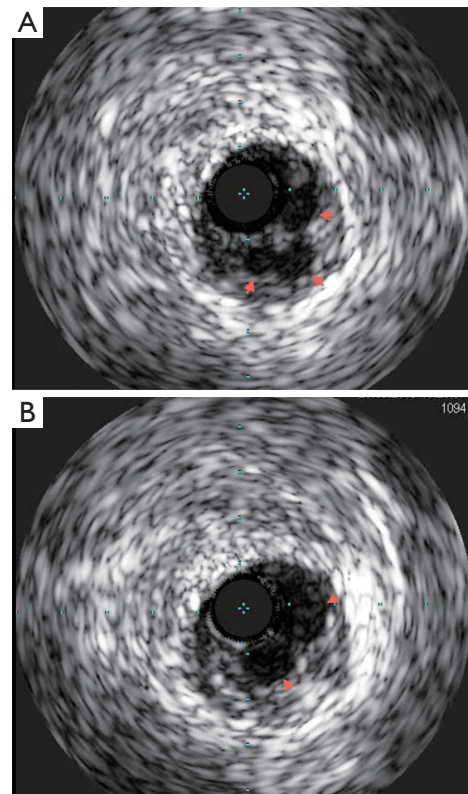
IVUS of the area of haziness showing multiple lumens (red arrowheads). IVUS, intravascular ultrasound.
